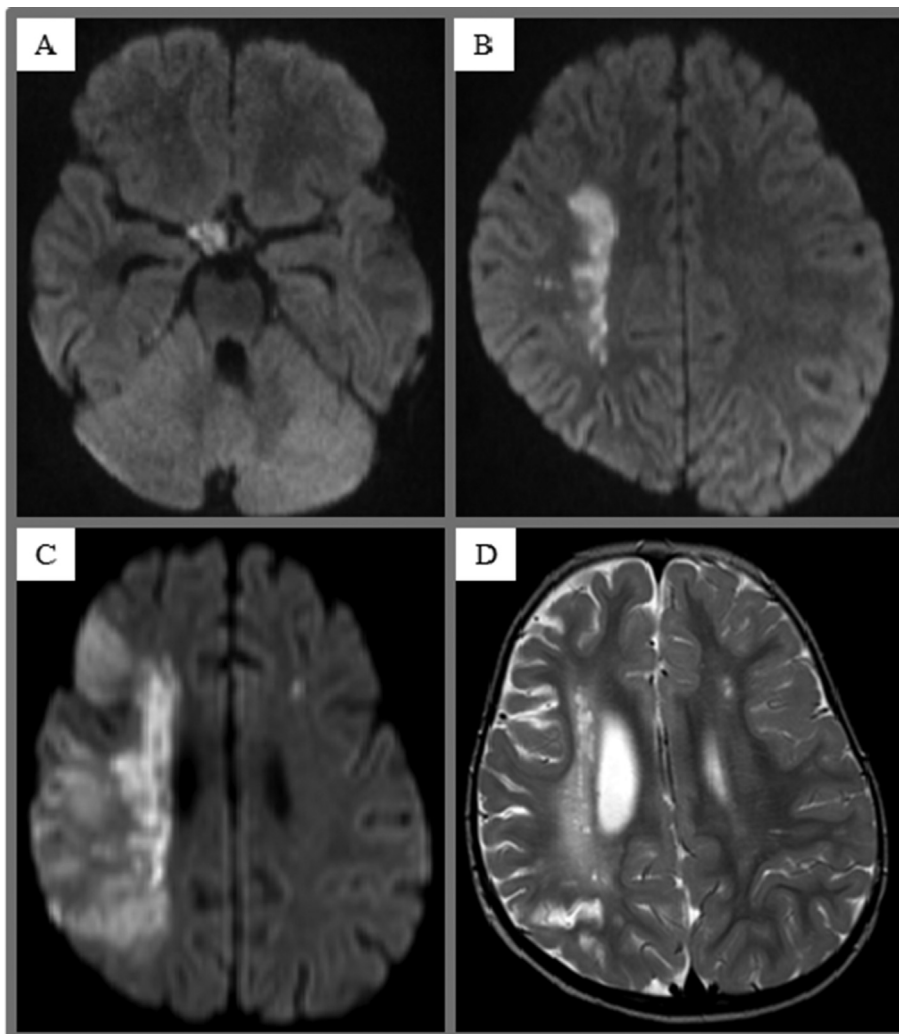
MRI Imaging of the cerebrovascular complications of skull base osteomyelitis in our case study. A: Initial unenhanced MRI: Axial diffusion weighted images showing material encircling the right supraclinoid internal carotid artery which demonstrates low value on apparent diffusion coefficient (ADC) map. B: Initial MRI: axial diffusion weighted sequences demonstrating areas of acute infarction within the deep white matter of the right frontal lobe. C: Contrast enhanced MRI performed at day 7: Axial b1000 images from a diffusion weighted sequence demonstrating an extensive right middle cerebral artery territory infarct with further new focal infarcts in the left frontal white matter. D: Follow up at 6 months. Axial T2 weighted MRI image showing maturation of the known infarcts, including parenchymal damage with focal areas of gliosis and volume loss involving the MCA territory of the right cerebral hemispheres and to a lesser extent within the left frontal white matter. OUH Foundation Trust Image.
